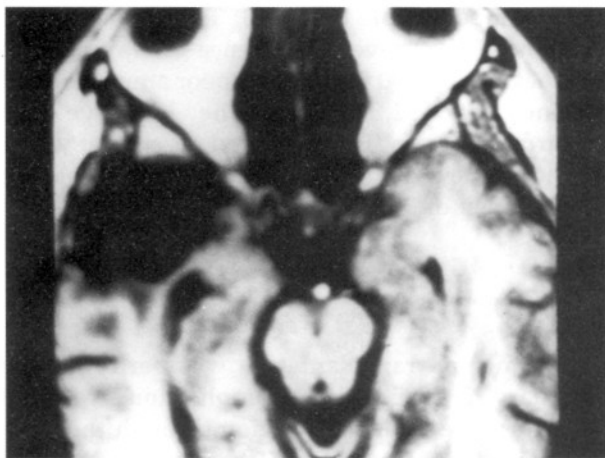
MRI scans done before surgery showing an infarct and a cyst in the right temporal pole.
